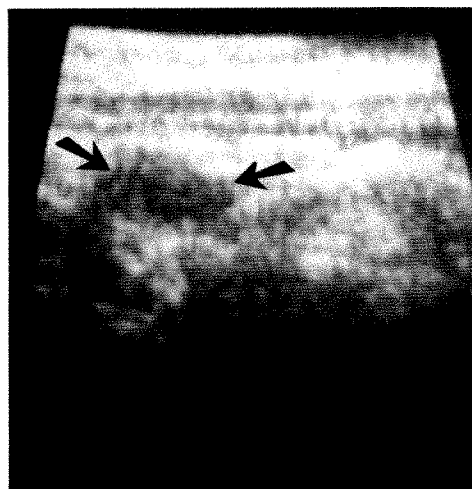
Sonograms showing the normal postthyroidectomy neck.
